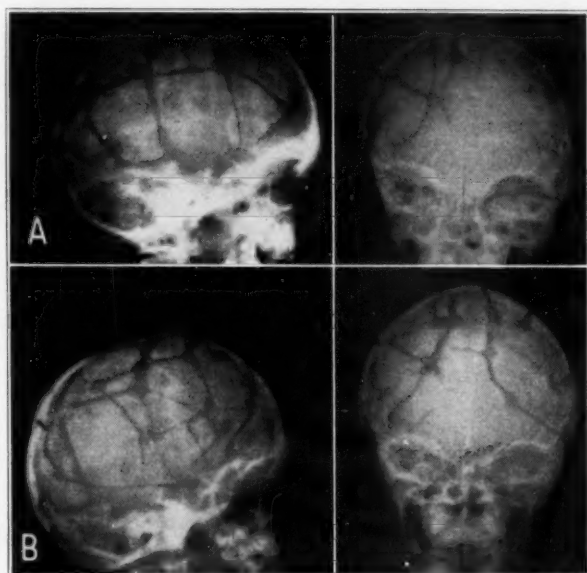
A*, roentgenograms made on Jan. 26, 1937, two and one-half months after the first operation. The grooves between the fragments are wider than when made. The lateral view shows the position of the skull fragments making a mosaic, and the anteroposterior view, the increase in size of the right side of the skull, with elevation of the fragments of bone and a contour rounder than that on the left. Convolutional markings have almost disappeared. *B*, roentgenograms made on February 3, one week after the second operation. By comparing them with the roentgenograms shown in figure 2, one can readily appreciate the difference in the shape, size and contour of the skull.
